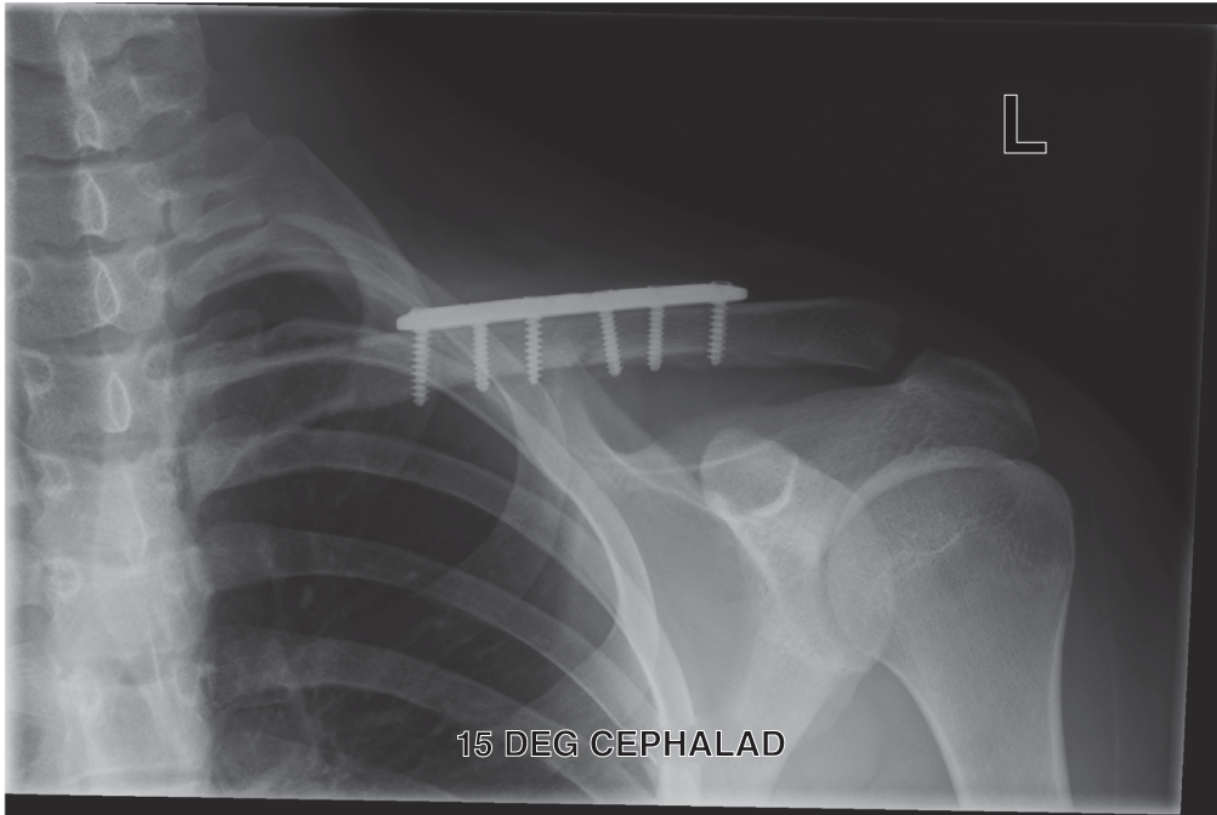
The patient in the case scenario elected to have operative treatment. This radiograph was obtained during follow-up and demonstrates fixation with a precontoured clavicle plate.
